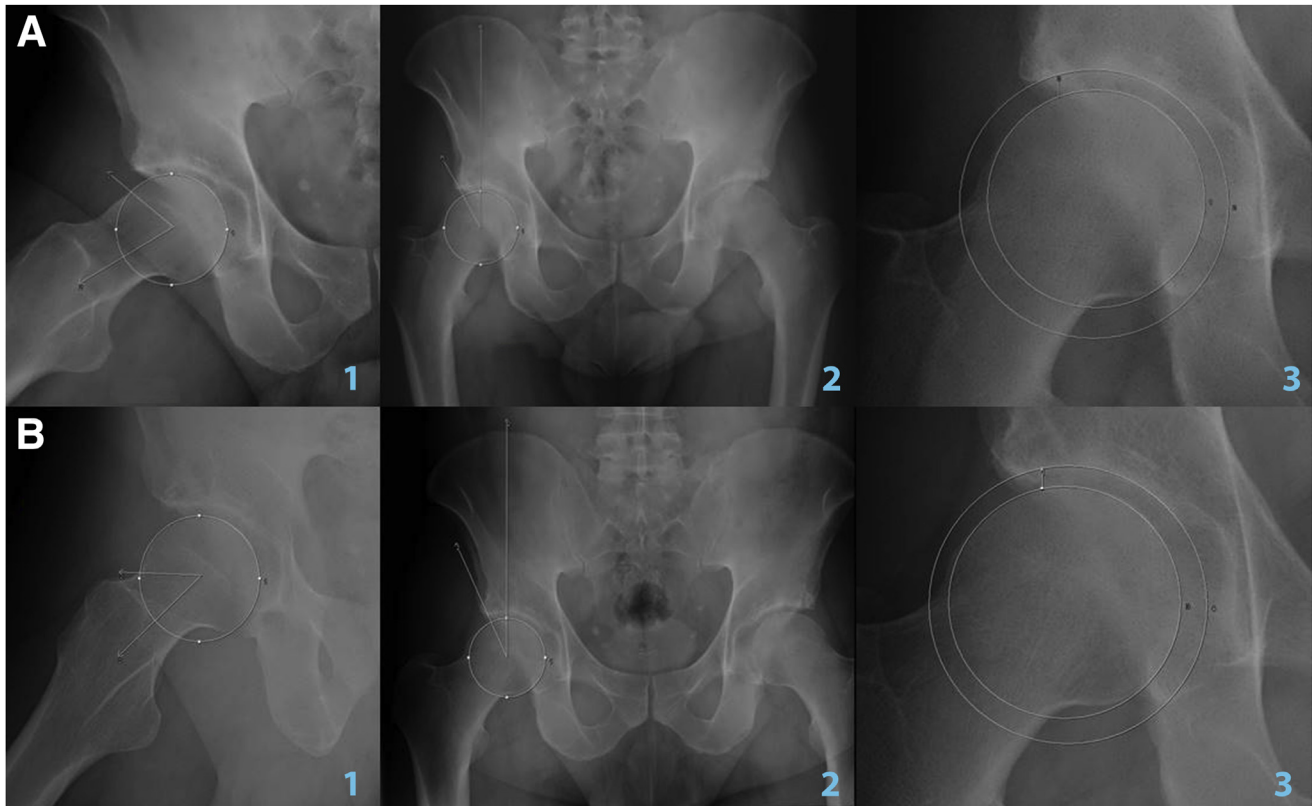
Anteroposterior (AP) and axial right hip radiographs, example of pre and postsurgical radiological measurements. (A) Upper row: (1) presurgery α -angle 70°; (2) center edge (CE) 29° (3) joint distance 50 mm. (B) Lower row: (1) postsurgery at 30 months α 45°; (2) CE 25° (3) joint distance 55 mm.
